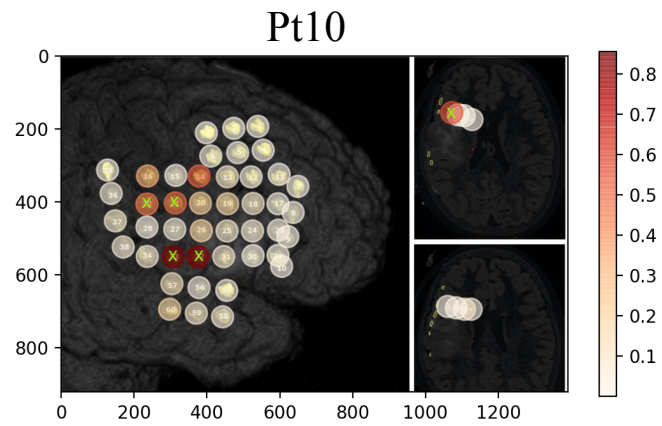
Visualization of electrodes with MRI scan image.
